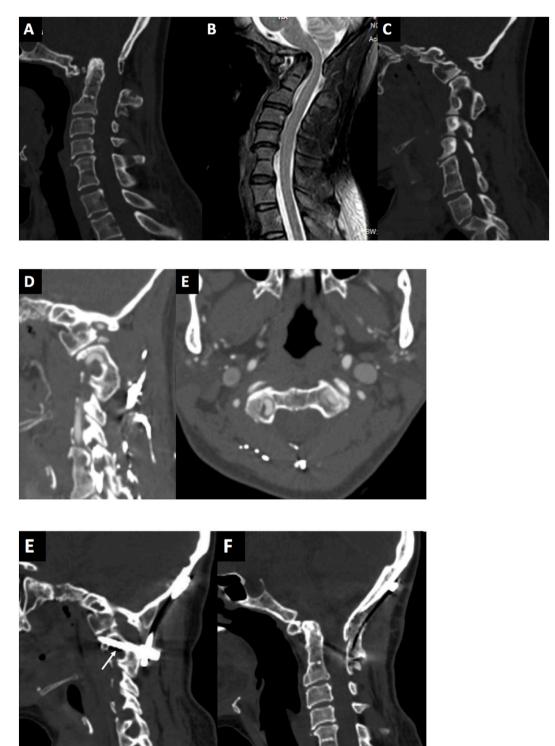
Case 11. A 53-year-old woman presented with neck pain, paresthesia and weakness of left extremities. A and B: Preoperative dynamic radiograph showing atlantoaxial instability, atlas assimilation and C2-3 fusion. C and D: CTA with multiplanar reconstruction demonstrating the right VA(arrow) enters spinal canal directly from C2 transverse foramen. E and F: CTA confirming HRVA(arrow) with a narrow C2 pedicle at the right side. G: Gentle Drilling of the bone above the isthmus, exposed the loop of vertebral artery and mobilized it inferiorly for C2 pedicle screw insertion. H: Using the plate screw instrumentation, occipitocervical fixation and fusion was performed. I: Postoperative x-ray showing complete reduction of the dislocation. J and K: Postoperative sagittal and axial CT scan showing a bone defect (arrow) above the isthmus, and the screw passed through the transverse foramen via mobilization of the vertebral artery.
